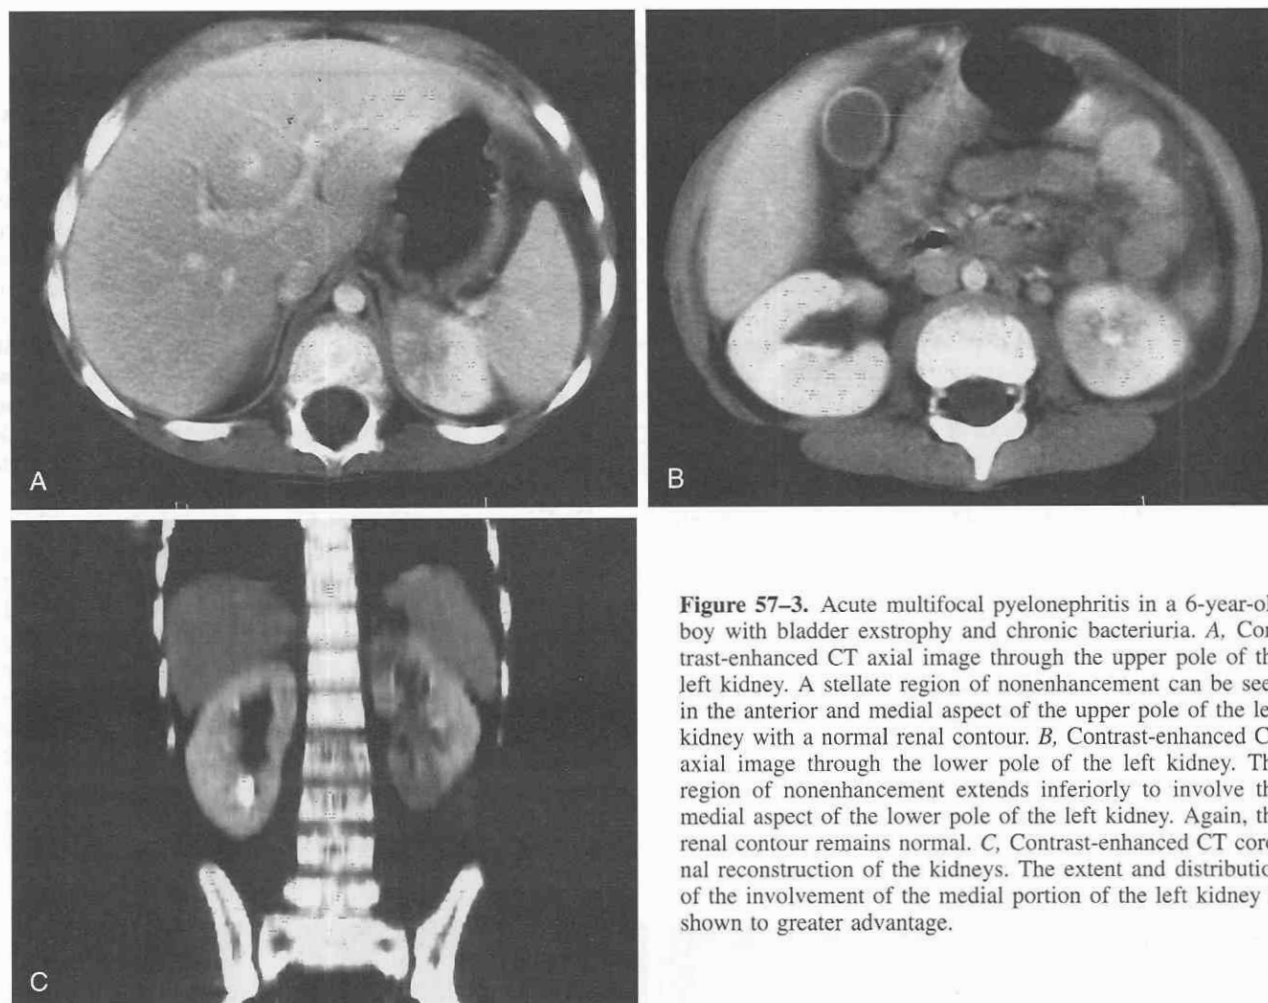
Acute multifocal pyelonephritis in a 6-year-old boy with bladder exstrophy and chronic bacteriuria. *A*, Contrast-enhanced CT axial image through the upper pole of the left kidney. A stellate region of nonenhancement can be seen in the anterior and medial aspect of the upper pole of the left kidney with a normal renal contour. *B*, Contrast-enhanced CT axial image through the lower pole of the left kidney. The region of nonenhancement extends inferiorly to involve the medial aspect of the lower pole of the left kidney. Again, the renal contour remains normal. *C*, Contrast-enhanced CT coronal reconstruction of the kidneys. The extent and distribution of the involvement of the medial portion of the left kidney is shown to greater advantage.
